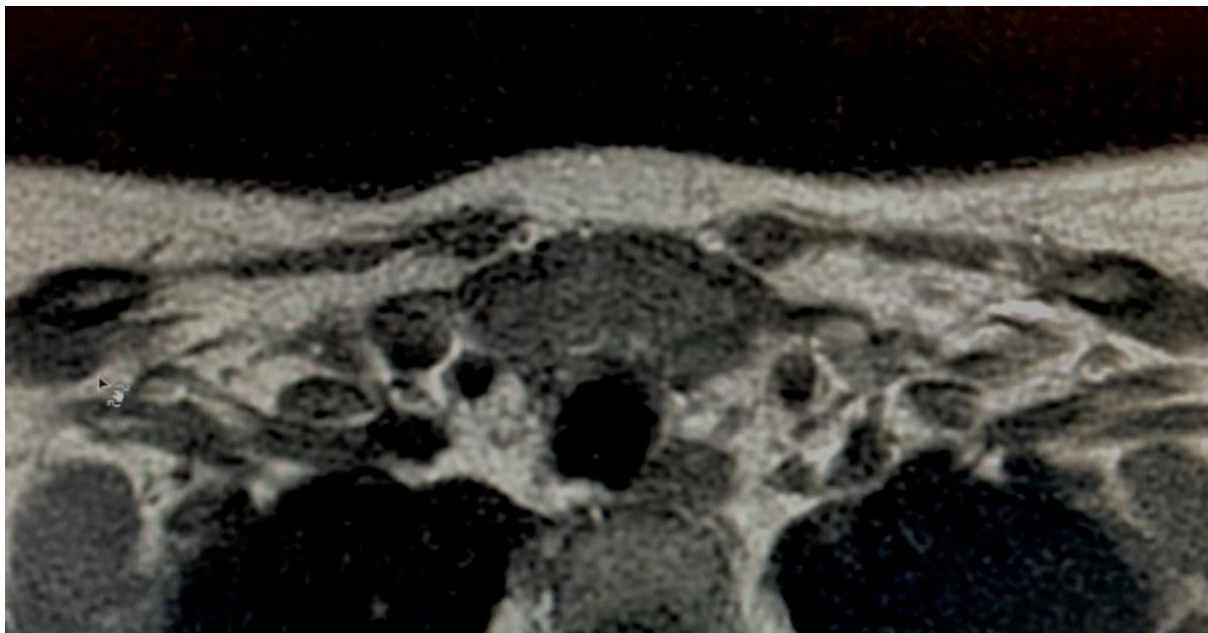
GD related TH, axial MRI feature at nine months' follow-up.
